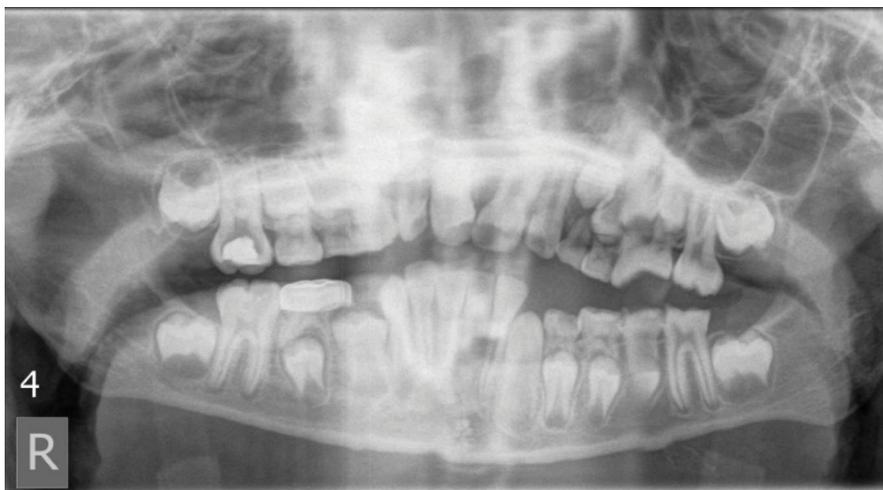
The orthopantomogram included with the referral resembled the appearance of supplemental teeth in the upper and lower left quadrants
